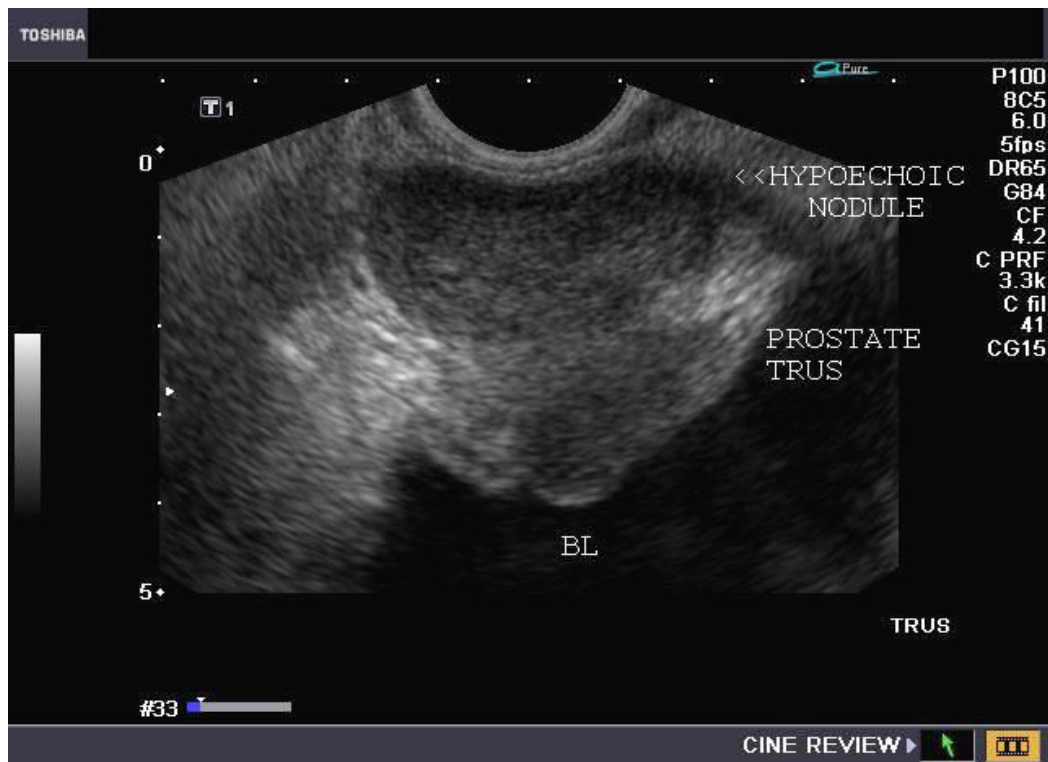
Shows sonographic appearance of adenocarcinoma of prostate..(Viable ultra sonnd CD.ROM)
